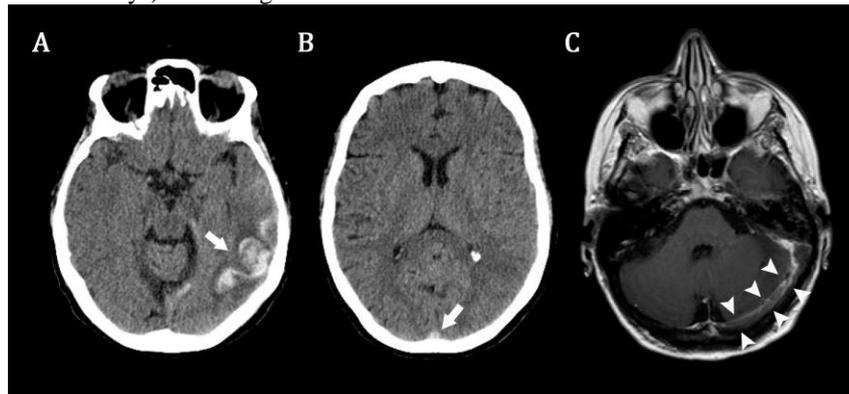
Unenhanced CT scan of the brain showing: (a) cortical-subcortical hemorrhagic lesion in the left posterior temporal region; (b) hyperdensity of superior sagittal sinus, i.e. the “dense triangle sign”. MR imaging of the brain showing, on axial gadolinium-enhanced T1-weighted imaging : (c) a hyperintense signal of the transverse sinus without enhancement of the lumen, i.e. the “double-track sign”.
